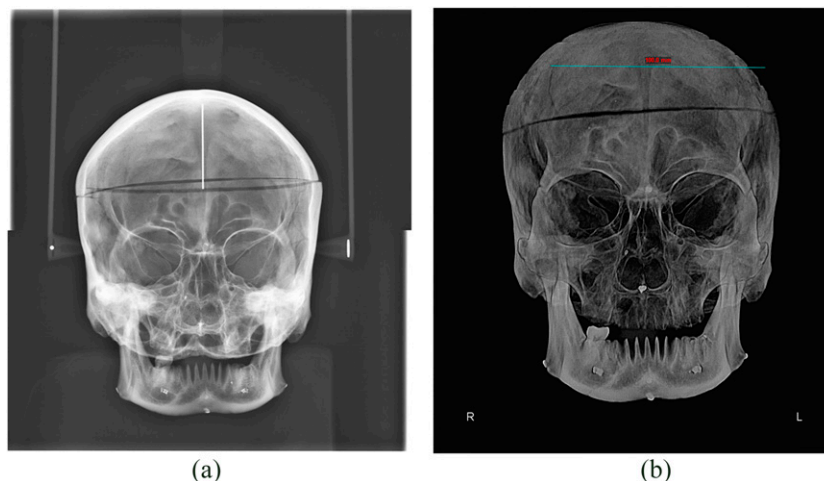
Taking conventional posteroanterior (PA) cephalograms (a) and CBCT PA cephalograms (b) of the skulls in the central position.
